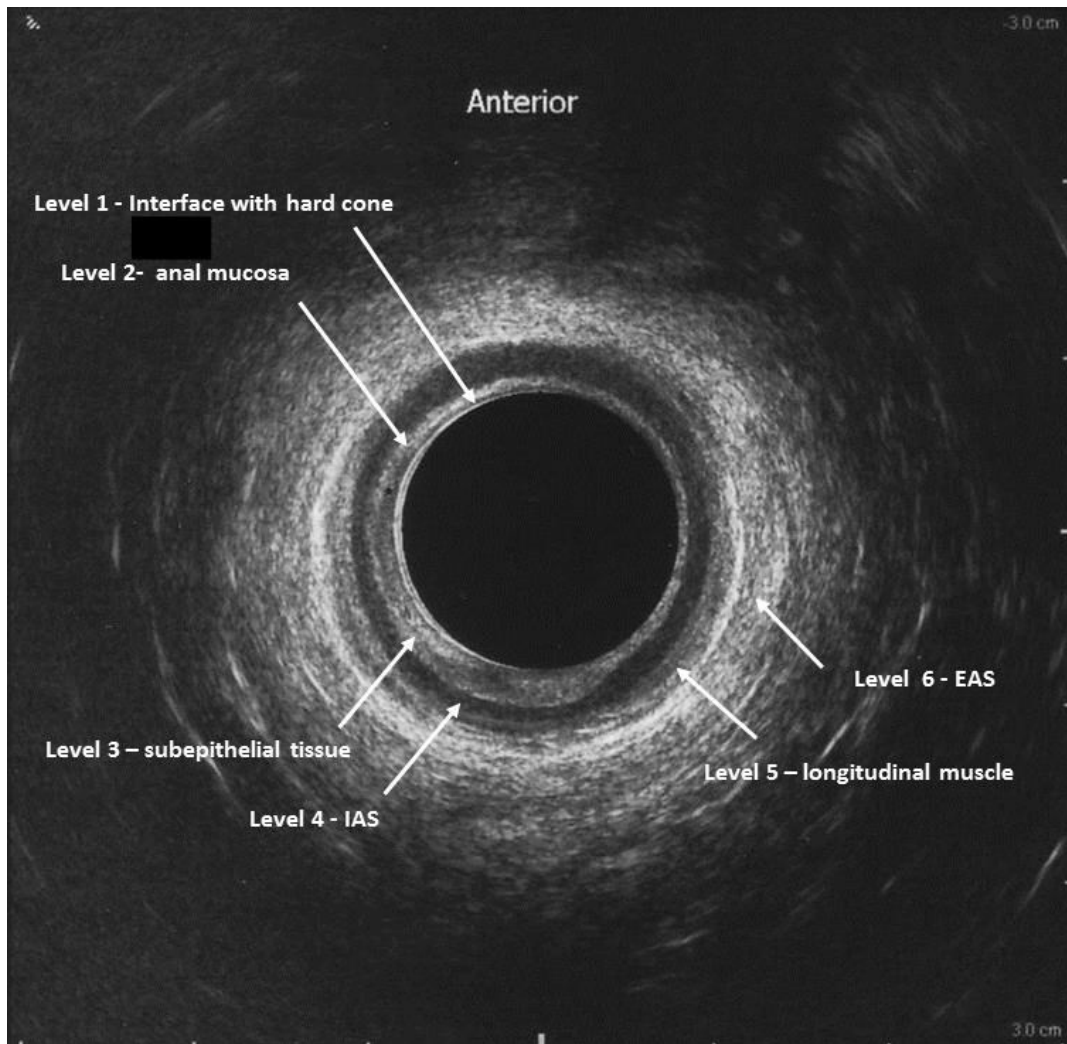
Ultrasound image showing the normal anatomy of the anal canal.
